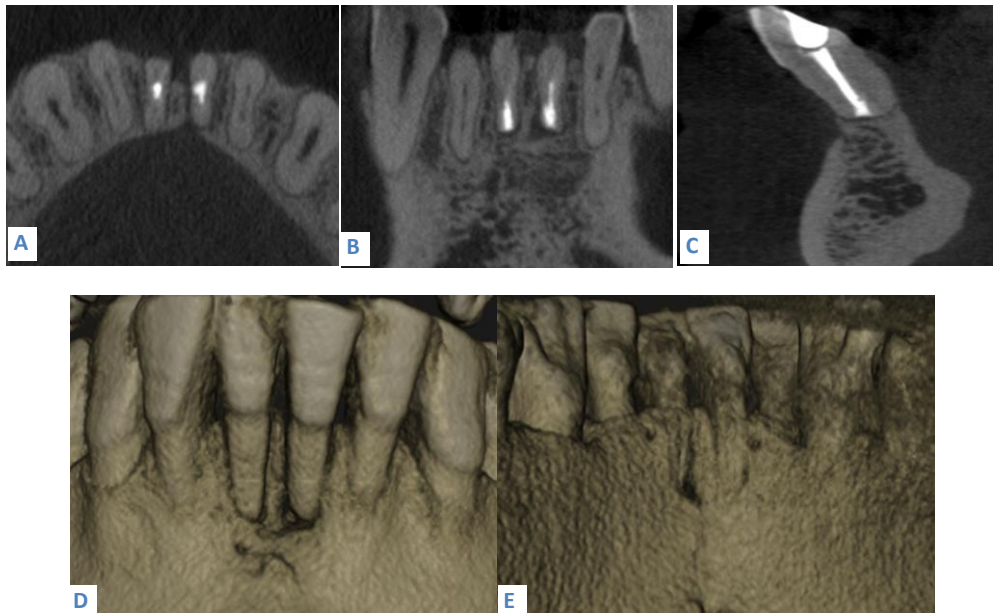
Post-operative CBCT
